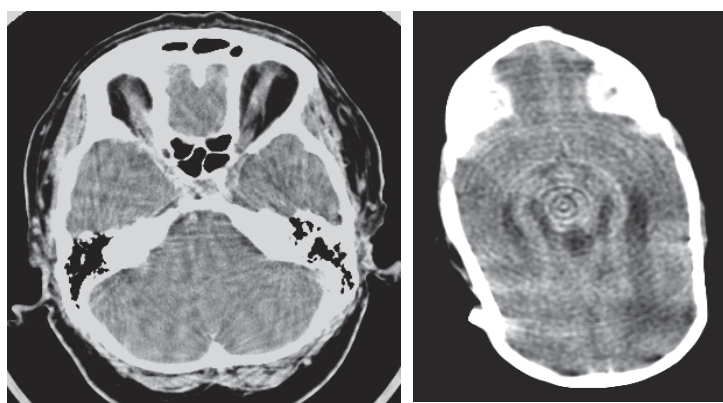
Artifacts that require x-ray CT scanner servicing. Left: vibrations of OTF relative to patient. Right: ring and band artifacts due to detector channel response drift. Reprinted from Toth (2012) with permission from Springer.
